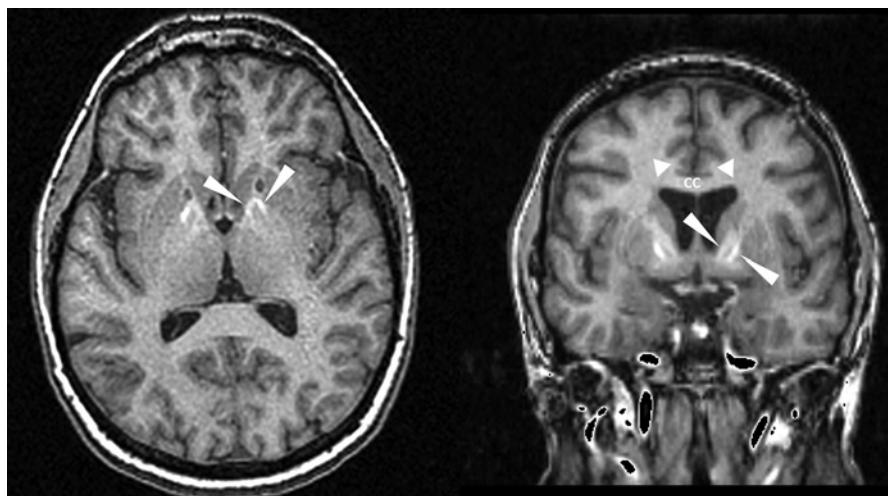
Sagittal, axial, and coronal MRI 1-year post-BAC. The capsulotomy, indicated by the arrowheads, is small and located in the most ventral aspect of the ALIC. VS, ventral striatum; DS, dorsal striatum.
